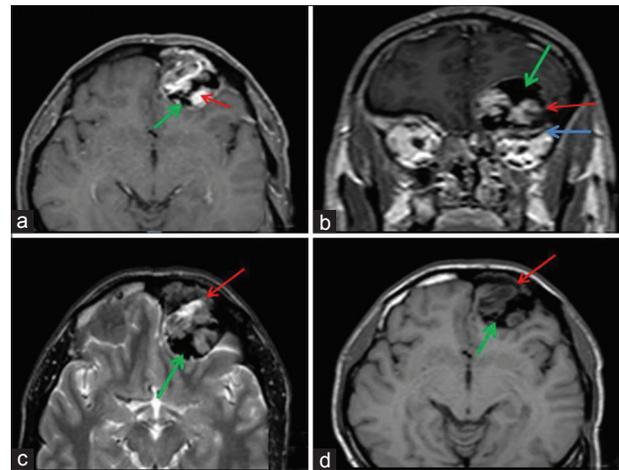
(a and b) Axial and Coronal spin echo postcontrast T1W images. Nonenhanced sclerotic component (green arrow) and strongly enhanced fibrous component (red arrow) are seen. On coronal section, mass effect upon left superior rectus muscle is seen (blue arrow). (c and d) On T2-weighted TSE and T1-weighted SE axial magnetic resonance imaging images show mass contained hypointense signal void regions (green arrow) and areas of calcification and intermediate intensity regions that represents areas of fibrosis (red arrow)
